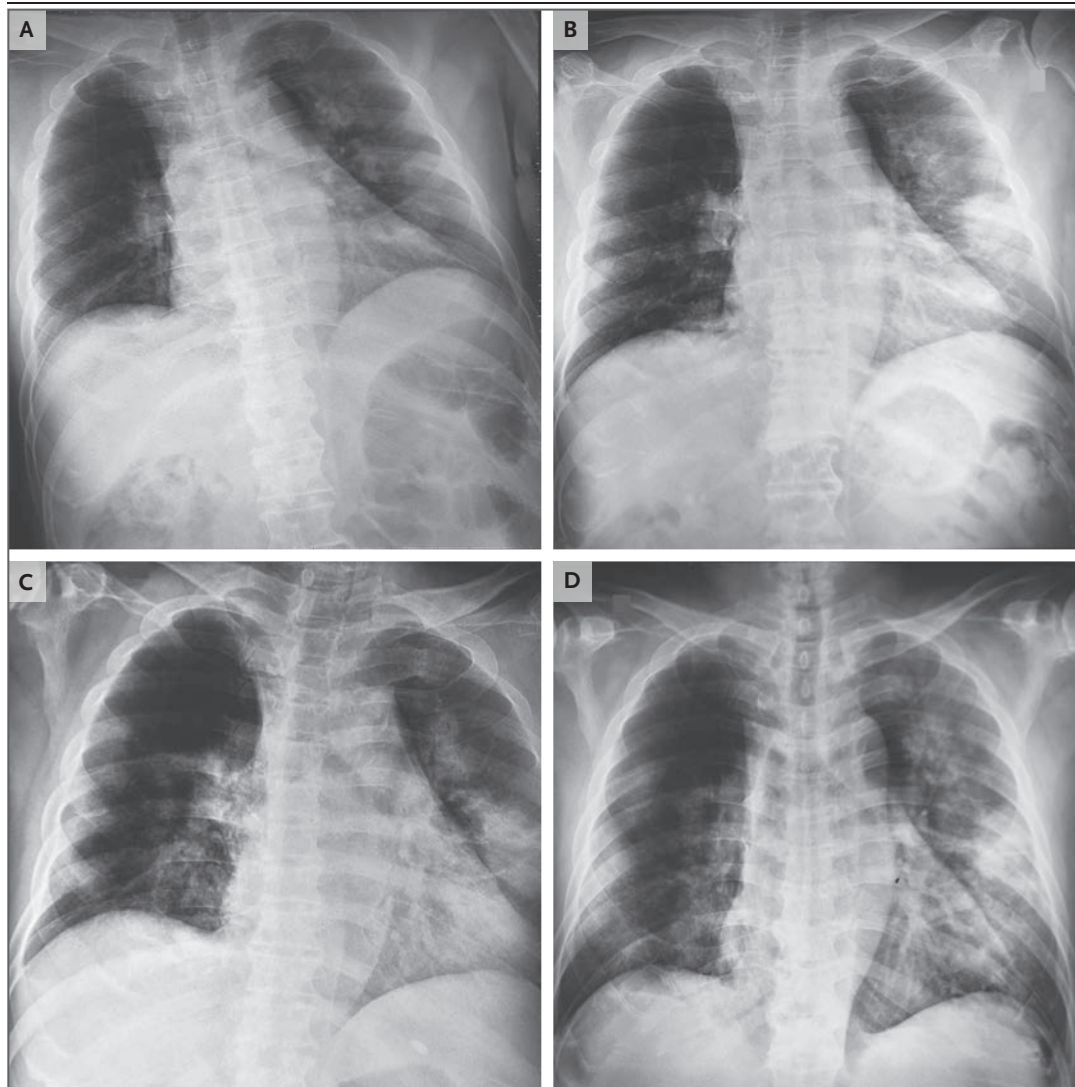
Radiographs of the Father's Chest.
